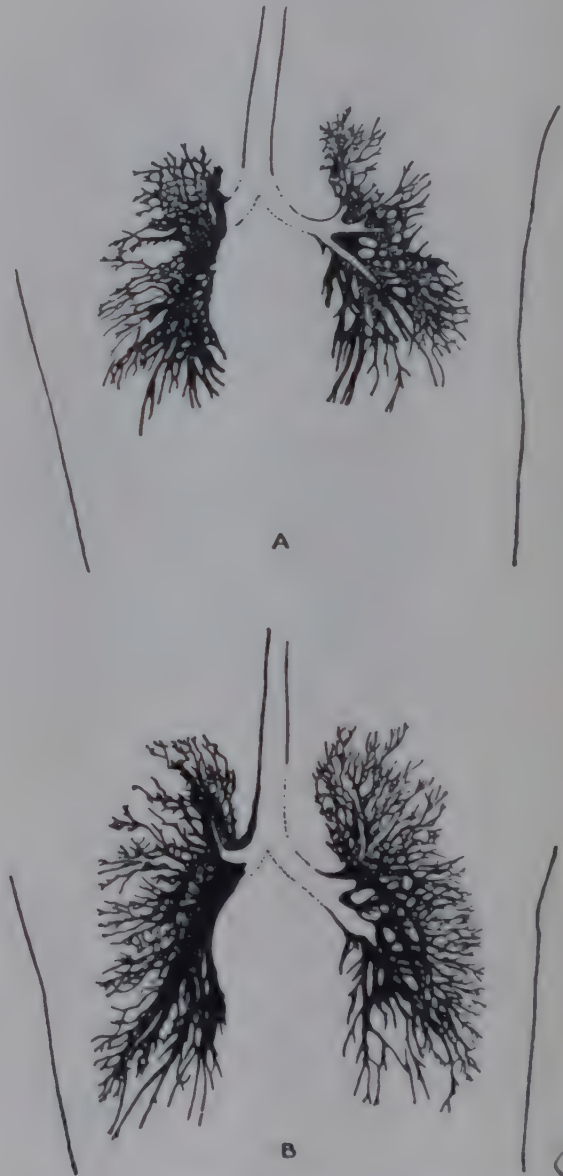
X-ray photographs (retouched) of the bronchial tree of a young woman: A, in full expiration; B, in full inspiration. (After Macklin.)
